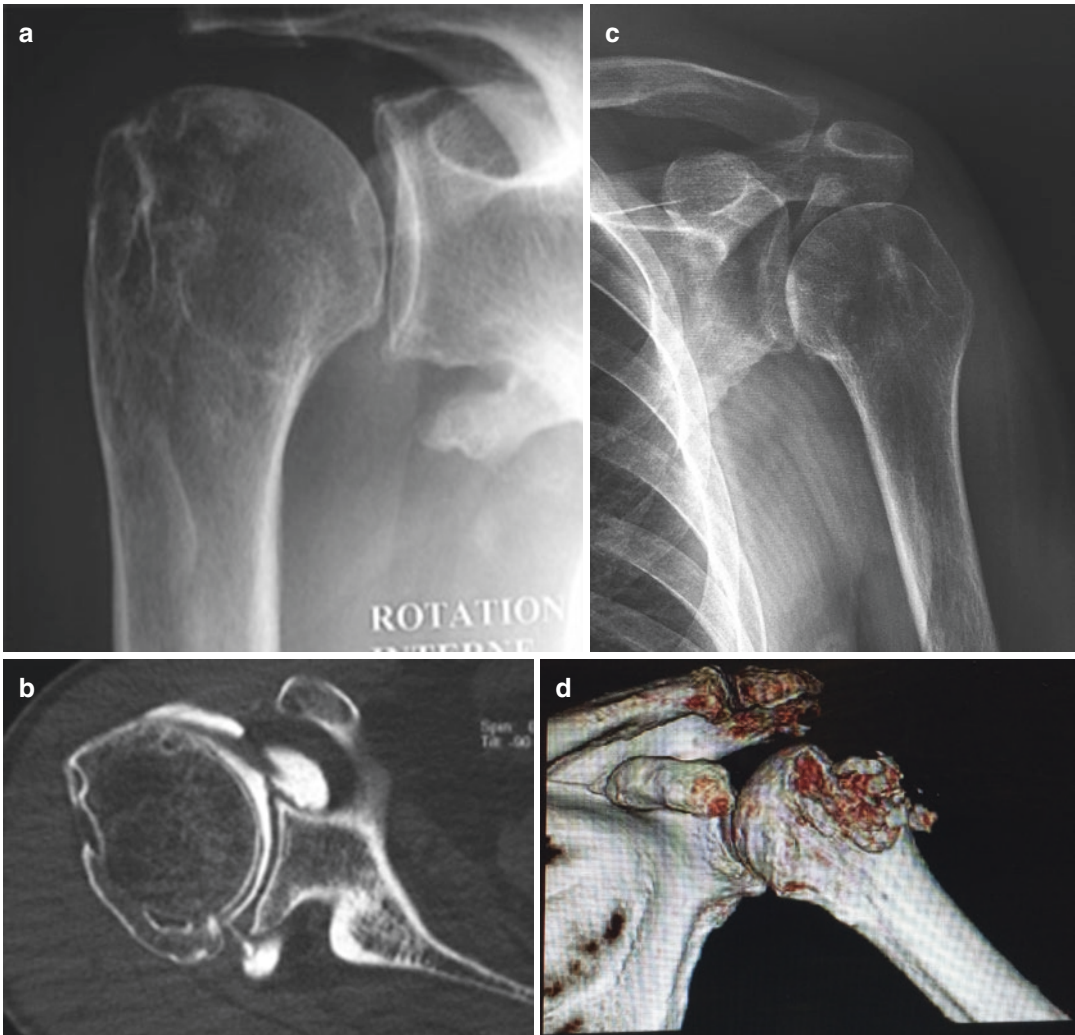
(a) A Grashey x-ray demonstrating a type 5 fracture sequela; (b) CT scan showing a posterior malunion of the greater tuberosity; (c) an AP x-ray showing a greater tuberosity nonunion that can mechanically block
